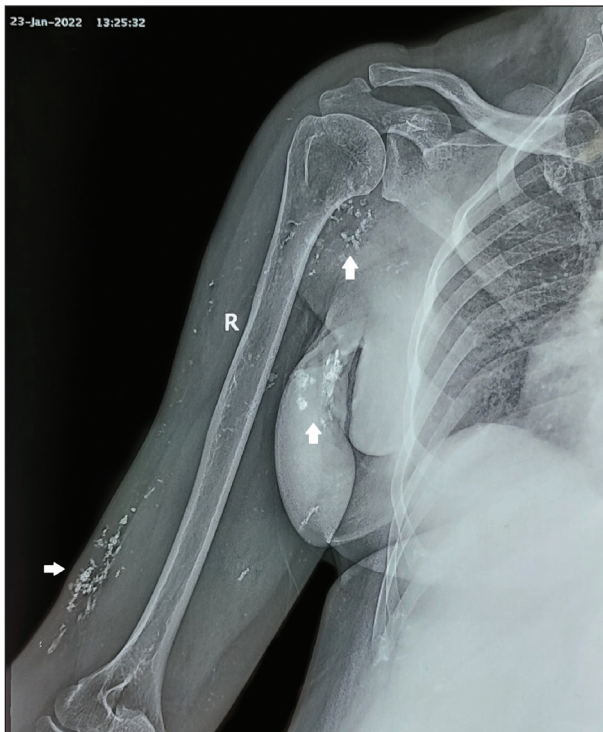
X-ray showing multiple calcifications (white arrows) over the right arm.
